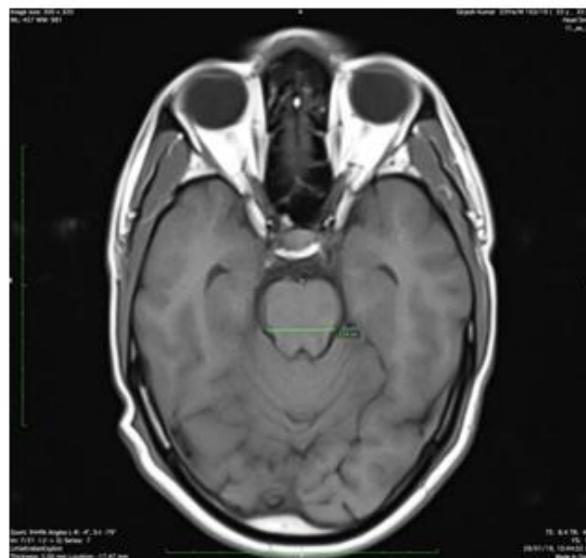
Showing width of fourth ventricle in MRI (at the level of lateral recess) (green line)
